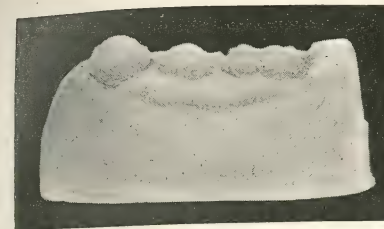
At the left is the model of lower teeth of miss, aged 14, with an abnormally shaped second bicuspid. The radiograph on the right shows the same in situ as seen by the X-rays. Its single root proves it to be the second bicuspid and not a retained temporary molar.
